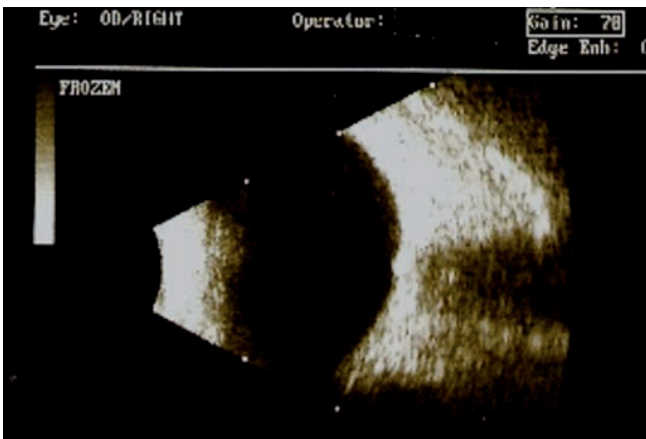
B-scan ultrasound examination of the right eye (patient no. 1). Visible hyperechogenic formations – drusen on level of ONH.
